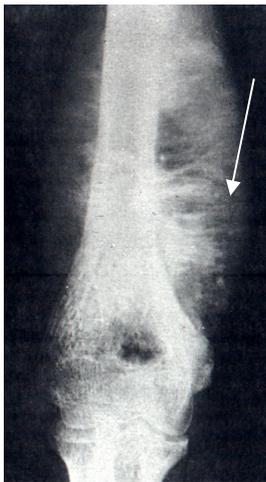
Enlargement radiograph of the shoulder in a direct projection. Evident spiculated-type periosteal reaction in distal metaphysis and diaphysis of the lower third of the humerus (arrow). Osteogenic sarcoma of the humerus.
